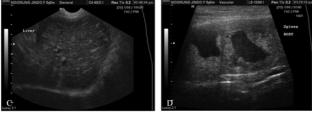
Close-up lateral (A) and ventrodorsal (B) thoracic radiographs of case 5 showing multiple pulmonary nodules (arrows), indicating metastasis. Ultrasonographic images (C, D) of case 5 showing metastatic changes in the hepatic and splenic parenchyma.
